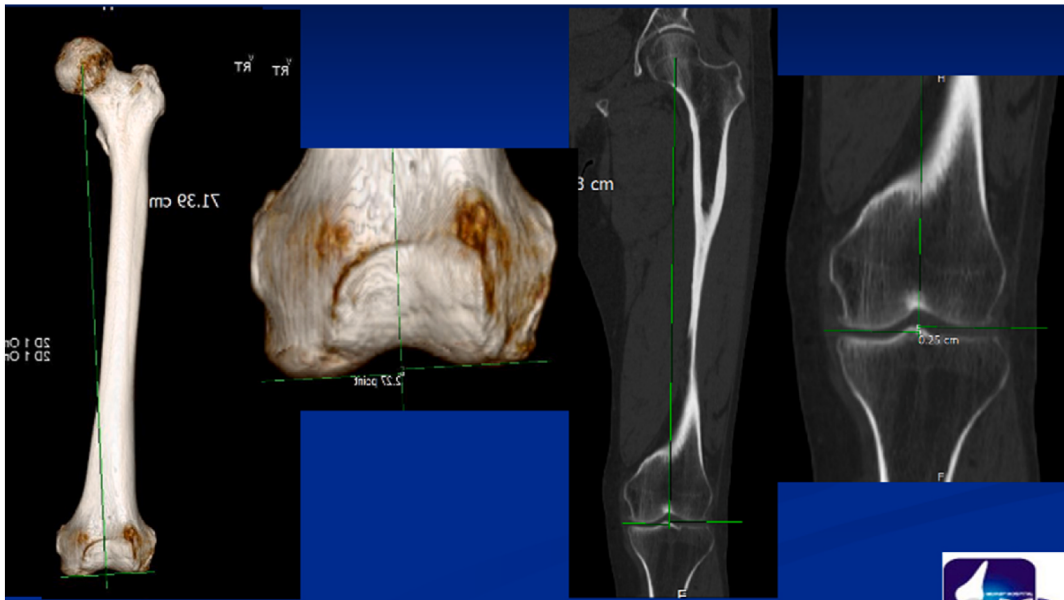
Measurement of condylar plateau line (CPL) using coronal section of computed tomography scan and three dimensional (3D) CT scan.
